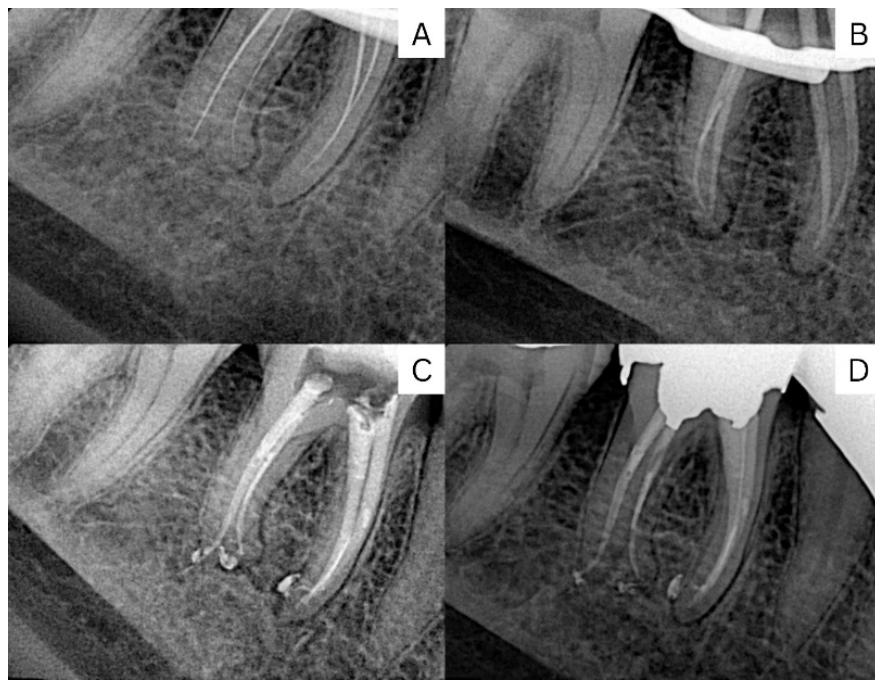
Figure Mandibular right first molar: A) working length determination; B) Master cone; C) final radiograph, obturation, apical seal, temporary restoration D) 9-month follow-up, coronal seal
